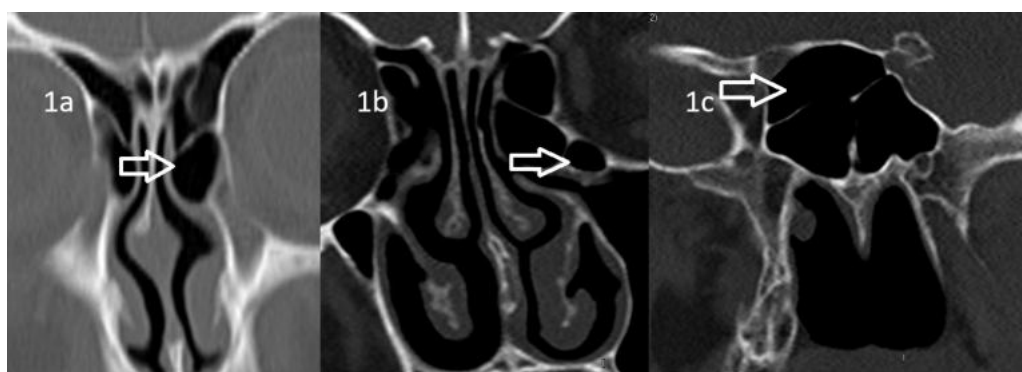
(a) In coronal section of the PSCT, Agger nasi cell (arrow). (b) In coronal section of the PSCT, Haller cells (arrow) and (c) In coronal section of the PSCT, Onodi cell (arrow). PSCT = paranasal sinus computed tomography
